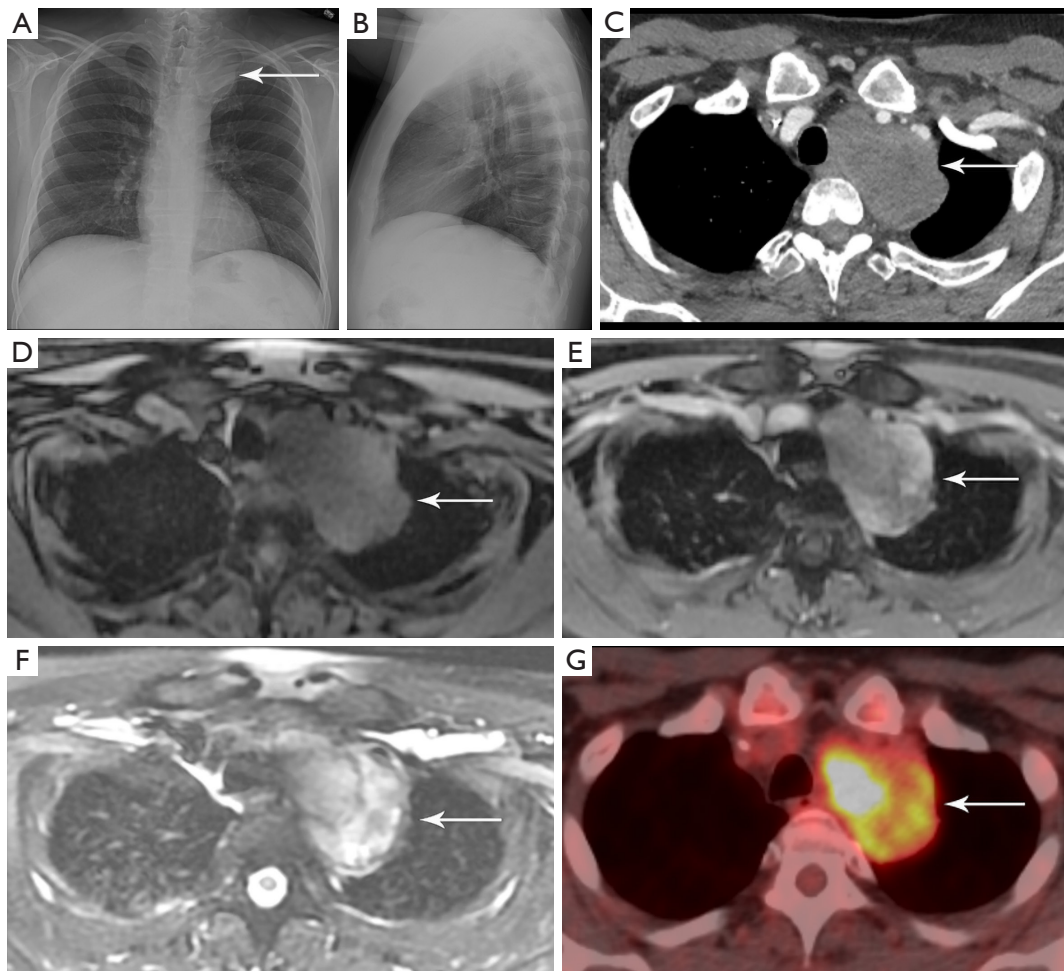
Schwannoma. (A,B) PA and lateral chest radiographs show a left mediastinal mass (arrow) in the upper thorax. (C) Axial contrast enhanced CT shows the mass (arrow) is solid with heterogeneous attenuation. (D) Axial T1-weighted MRI shows the mass (arrow) is iso-intense to muscle. (E) Axial T1-weighted post-contrast MRI shows the mass (arrow) enhances heterogeneously. (F) Axial T2-weighted MRI shows the mass (arrow) is heterogeneously hyperintense with cystic areas. (G) Fused PET/CT shows the mass (arrow) is FDG avid. Biopsy confirmed schwannoma. PA, posterior anterior; CT, computed tomography; MRI, magnetic resonance imaging; PET, positron emission tomography; FDG, fluoro-2-deoxy-D-glucose.
